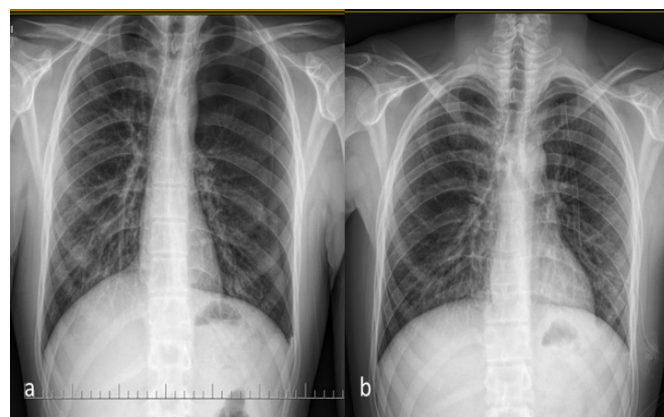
a) Chest radiograph of pneumothorax b) Chest radiograph of primary spontaneous pneumothorax after chest tube, left hemithorax is re-expanded
